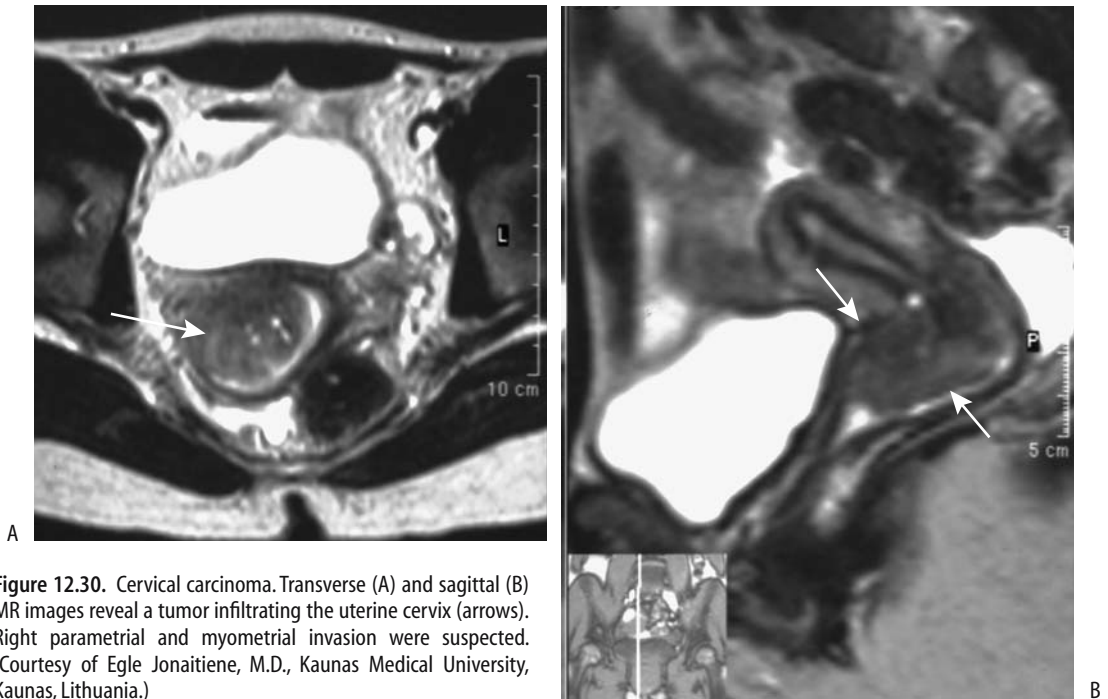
Cervical carcinoma. Transverse (A) and sagittal (B) MR images reveal a tumor infiltrating the uterine cervix (arrows). Right parametrial and myometrial invasion were suspected. (Courtesy of Egle Jonaitiene, M.D., Kaunas Medical University, Kaunas, Lithuania.)
